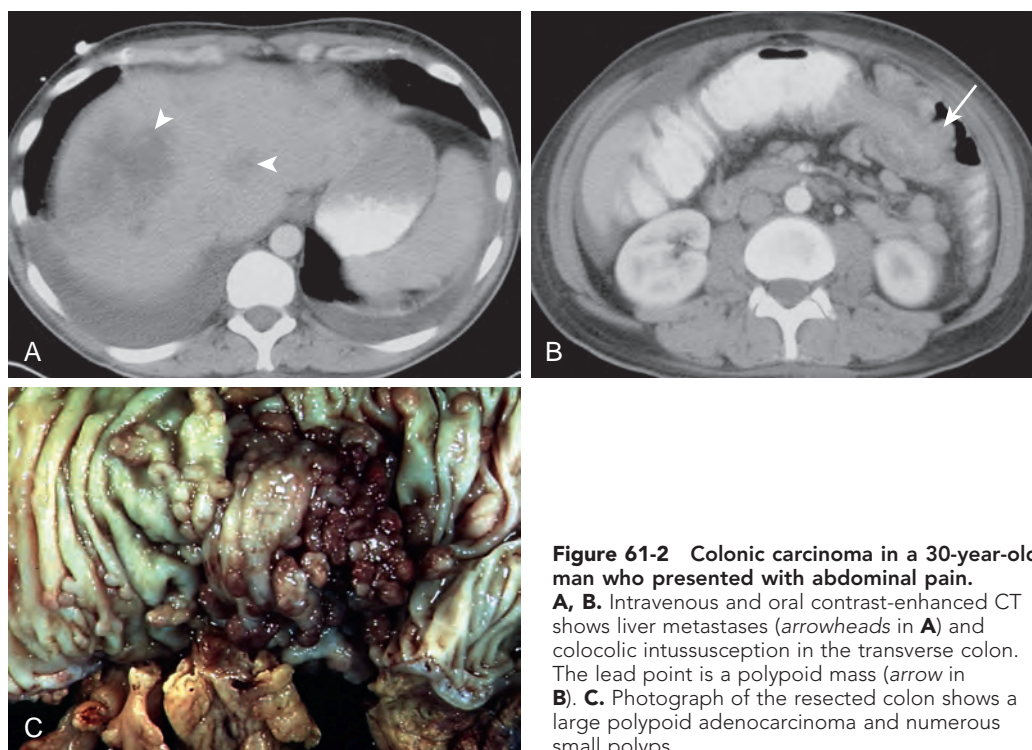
Colonic carcinoma in a 30-year-old man who presented with abdominal pain. A, B. Intravenous and oral contrast-enhanced CT shows liver metastases (arrowheads in A) and colocolic intussusception in the transverse colon. The lead point is a polypoid mass (arrow in B). C. Photograph of the resected colon shows a large polypoid adenocarcinoma and numerous small polyps.
